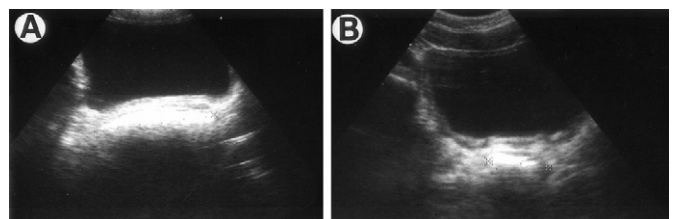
Transverse view of ultrasound. A, bladder in constipated patient with bladder base compressed by fecal mass in distended rectum. B, normal rectum in nonconstipated patient.
